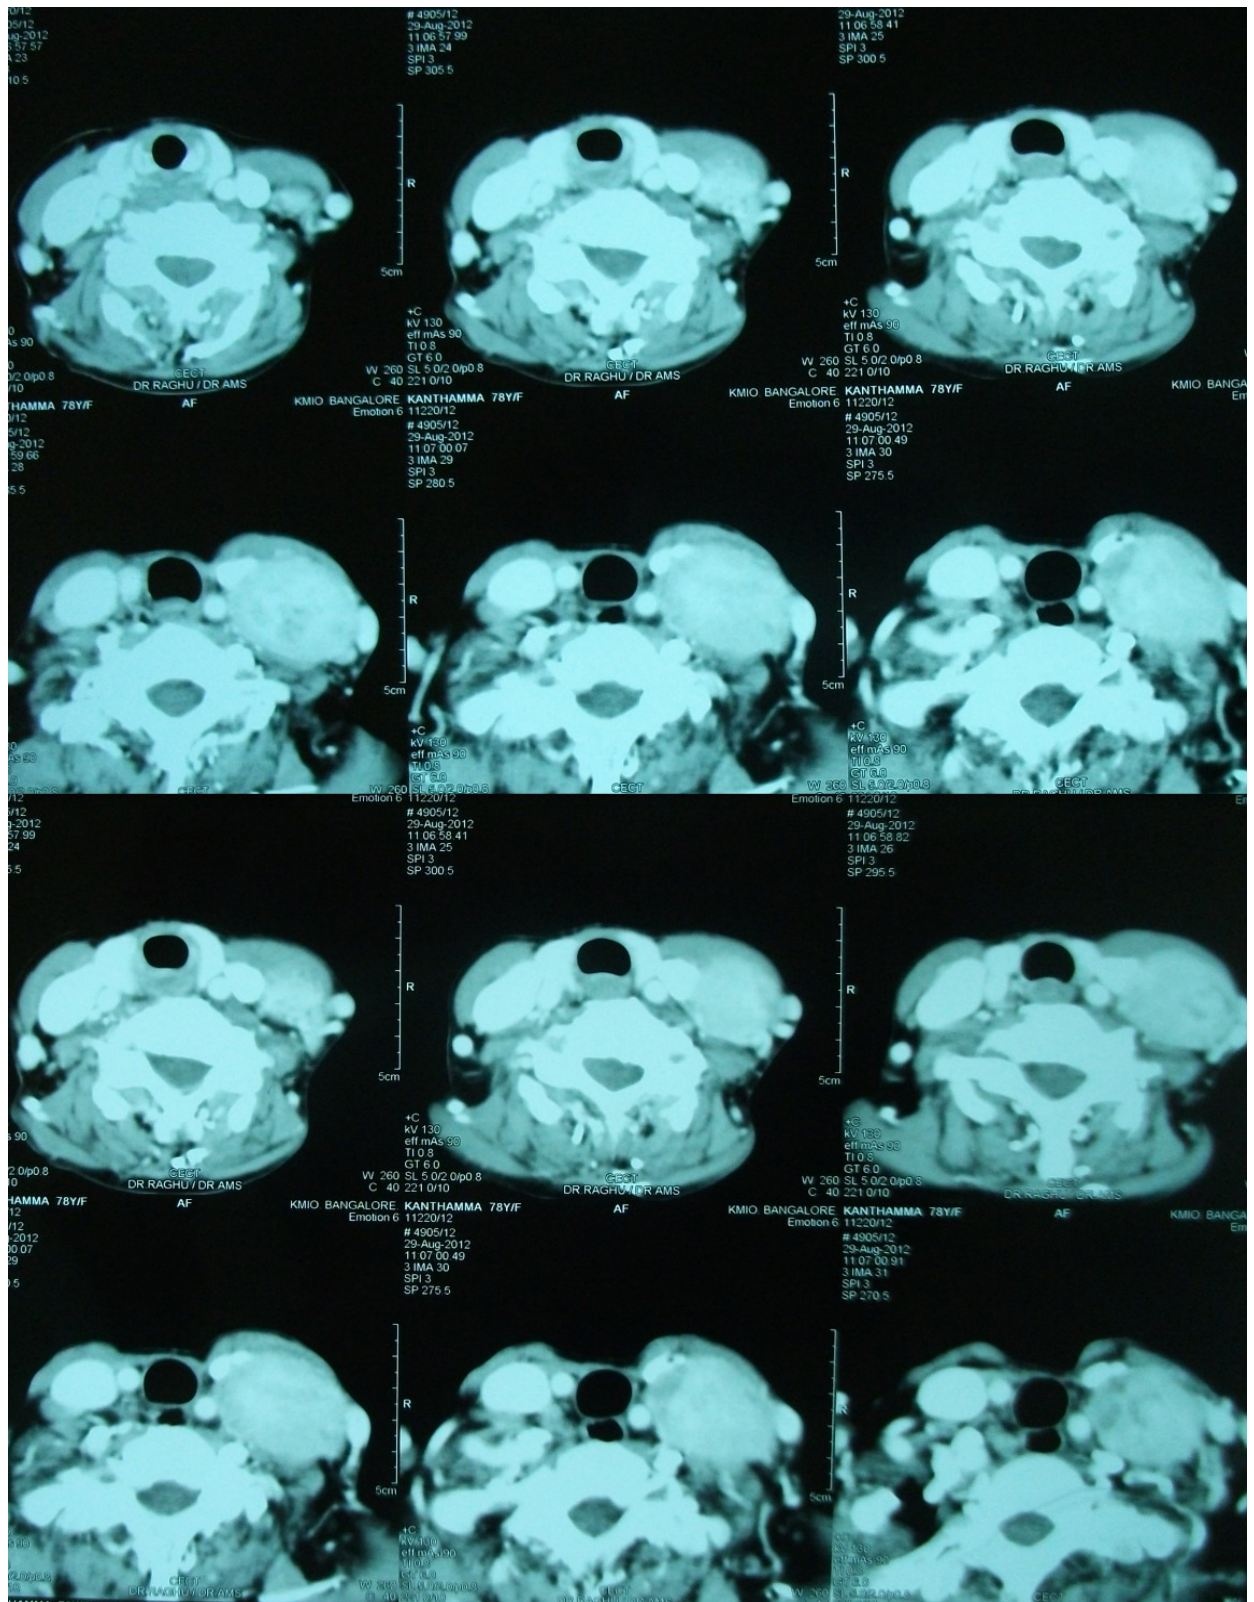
Axial CT scan showing (L) level IV lymph node mass with a small thyroid
